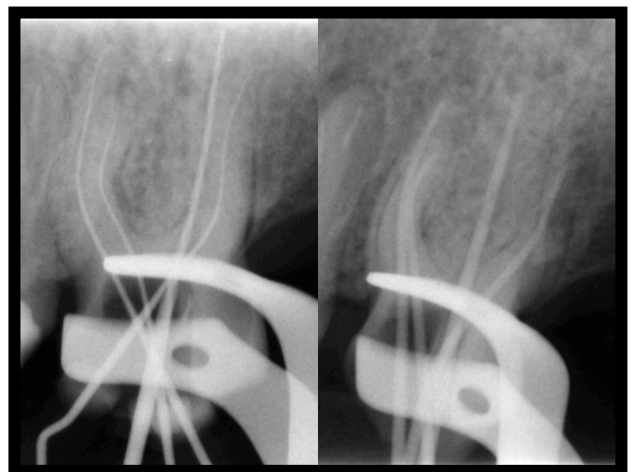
Working length and masterpoint radiograph
